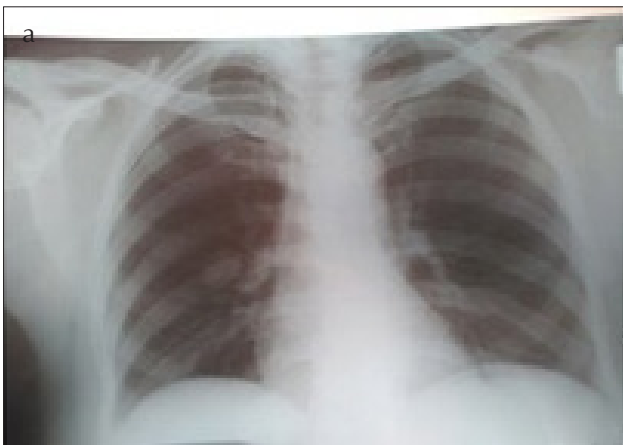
a, b. Case 2- (a) Rare limited density increase of about 2 cm in the right hemithorax in the lower zone of the posterioranterior lungs (b) Thoracic CT revealed a solitary pulmonary nodule with 1.8 cm in diameter localized in the right upper lobe posterior segment
